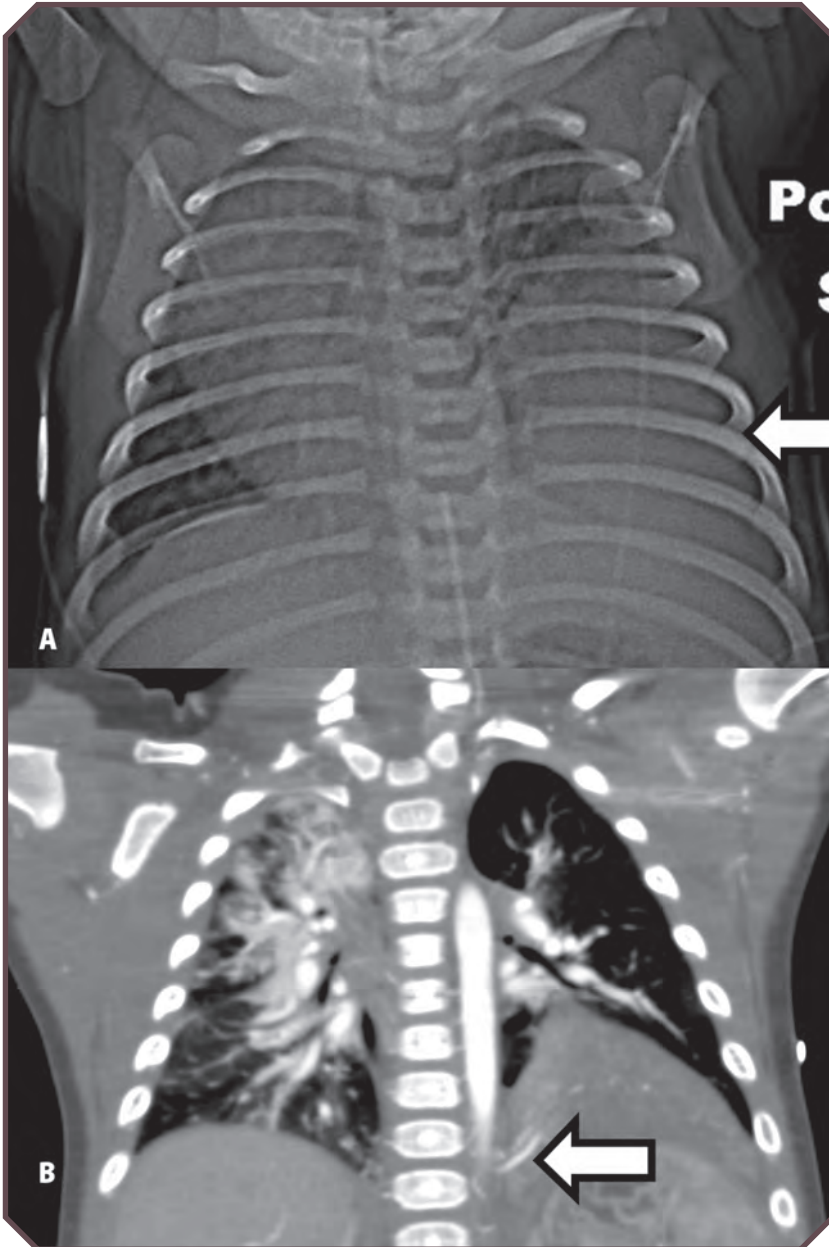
Extrapulmonary sequestration in a 5-month-old male infant. A. Frontal chest radiograph shows a left lung base opacity (arrow). B. Coronal reconstructed computed tomographic image obtained with contrast material confirms a density in the left lung base and demonstrates a vessel that extends from the aorta (arrow). These findings are diagnostic for sequestration.
